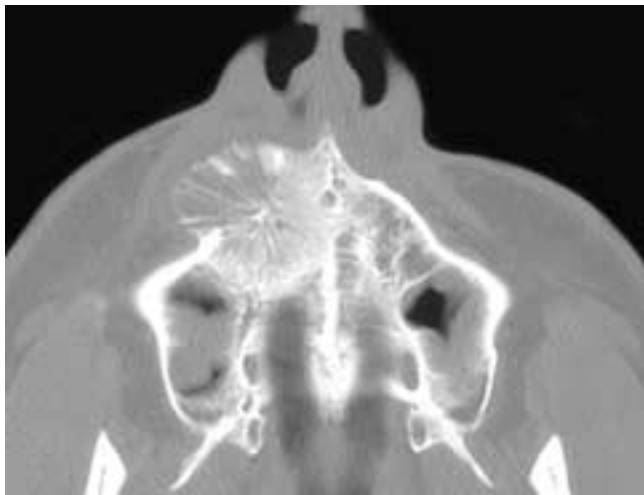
Axial CT scan shows a destructive mass in the right anterior maxilla with a typical “sunburst”-type periosteal reaction. This patient had an osteogenic sarcoma.
